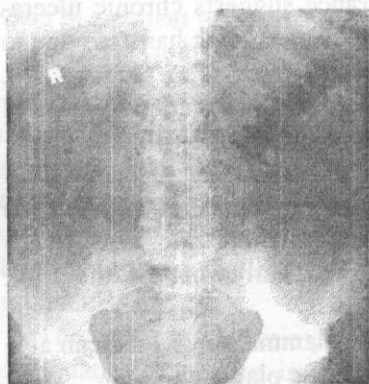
Plain abdominal radiograph from a patient with known ulcerative colitis who presented with an acute exacerbation of his symptoms. This image shows thumbprinting in the region of the splenic flexure of the colon.
